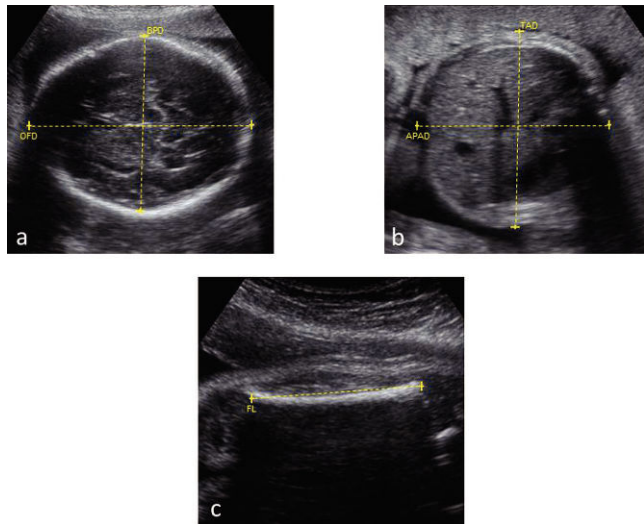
Ultrasound images demonstrating the transverse section of the fetal head (A), abdomen (B) and femur length (C). Markers are placed depicting measurements of the biparietal (BPD), occipitofrontal (OFD), antero-posterior (APAD) and transverse abdominal (TAD) diameters and femur diaphysis length (FL).
